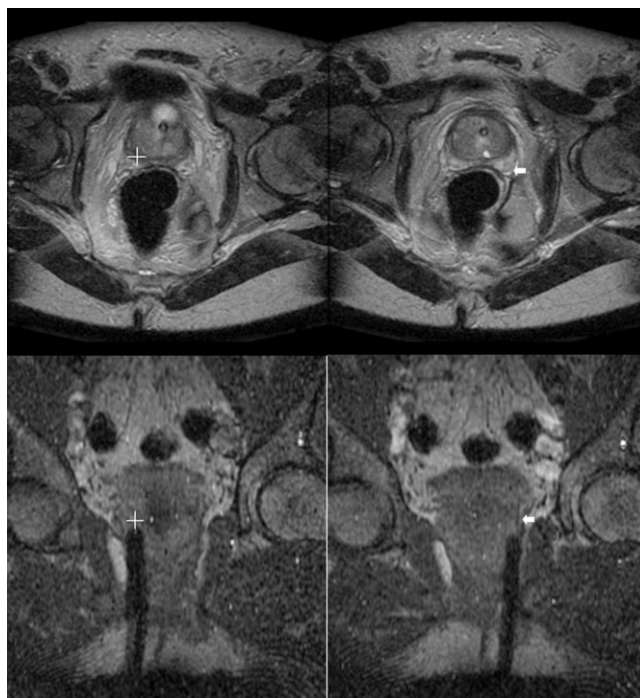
Representative MR images from clinical studies (60 years old; PSA = 8.3 ng/dL; prostate volume = 19.0 cc). Images on the top row are preprocedural T2-w images of (top left) tumor target site near the right lateral base (cross mark) and (top right) a sextant-sampling site at the left lateral base of the prostate (arrow). Images on the bottom row indicate typical needle angling with slight deflection visible in coronal coherent gradient echo images. In particular, the bottom left image shows the needle advancing toward the tumor target site near the right lateral base (cross mark) and the bottom right image shows the needle advancing toward the sextant target in the left lateral base (arrow).
